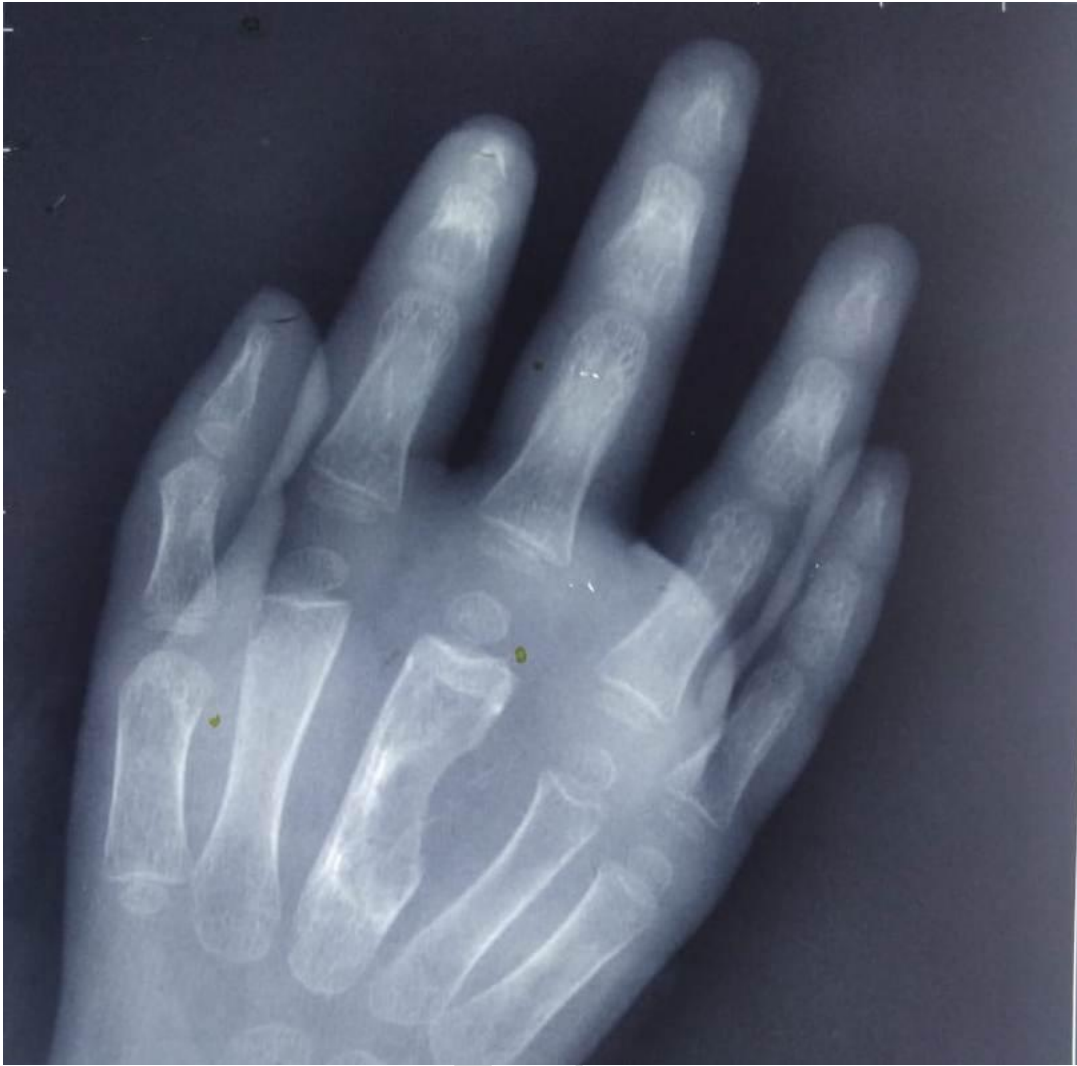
Radiograph showing scalloping of the 3rd meracarpal , subtle cortical irregularities and Osteopenia
